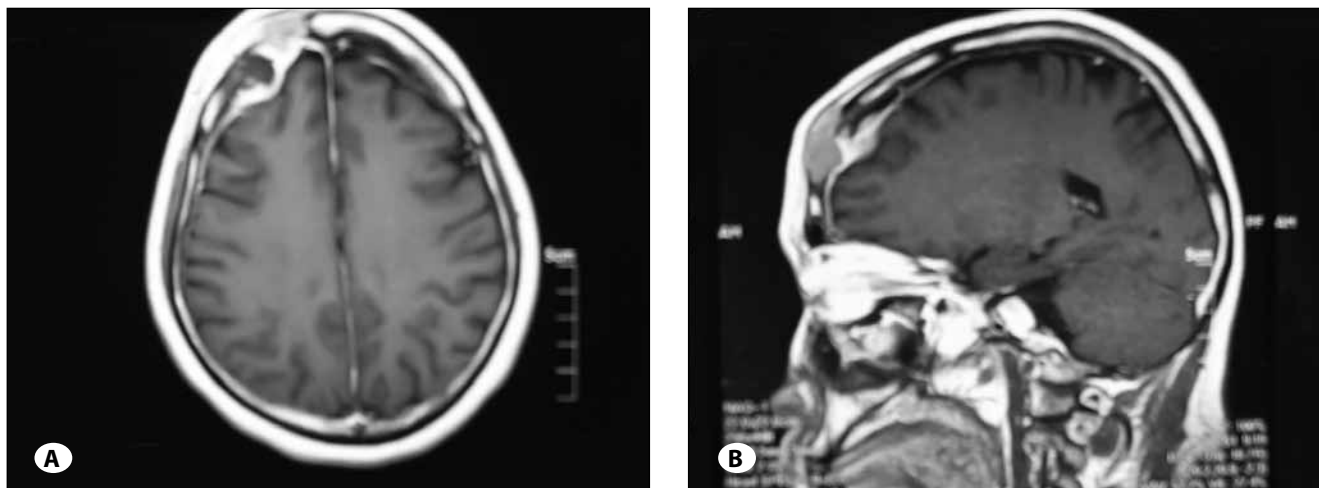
A) Axial and B) Sagittal T₁ weighted MR image with gadolinium contrast demonstrates a homogeneously-enhanced mass lesion in the right frontal area that has invaded the dura and skull.
